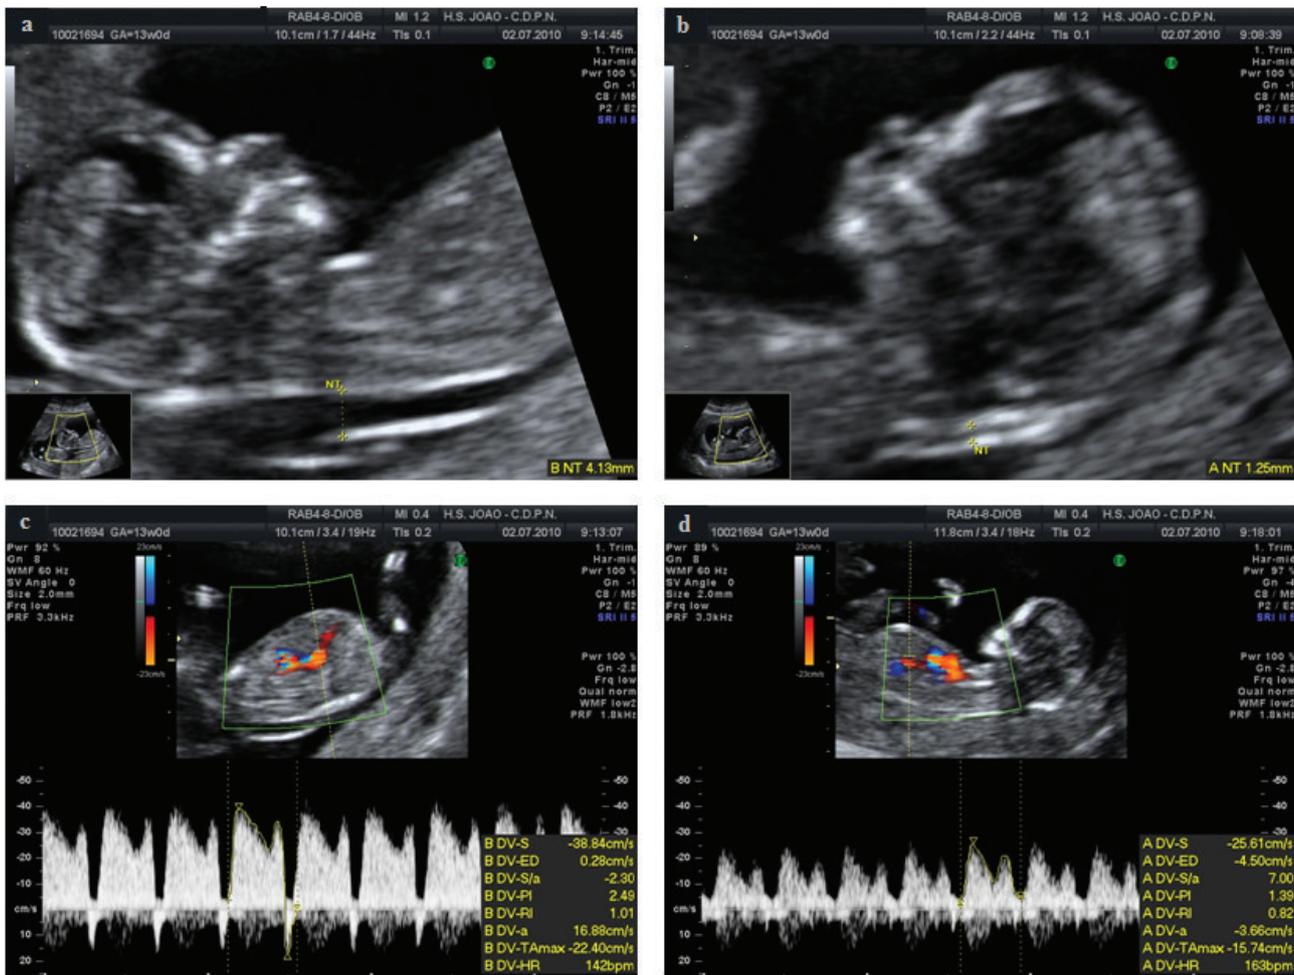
Ultrasound images from a monozygotic diamniotic twin pregnancy diagnosed at 13 weeks' gestation. There is a nuchal translucency (NT) discrepancy (NT = 1.25, 4.13 mm) (a,b). One of the fetuses presents abnormal flow in the ductus venosus (DV) with reversed A-wave (c), whereas the other has normal blood flow waveforms in the DV (d).
